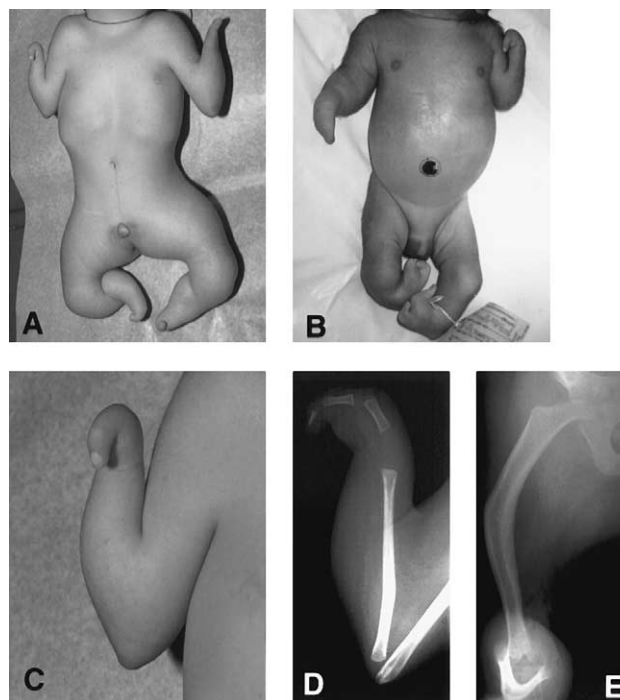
Photographs and radiographs of patients. A, Patient 1. B, Patient 2. Severe symmetric limb malformations are present in all four limbs. A proximal segment or stylopod, an intermediate segment or zeugopod, and a distal segment or autopod are present in each limb. Single digits with a dorsal nail are present in all limbs in patient 1; two digits are present in the feet in patient 2. In patient 1, the external genitalia are represented by a rugous scrotal skin, where no testes were palpable, and a small phallus with a distal urethral opening. Patient 2 has penoscrotal transposition and micropenis. C, Right upper limb of patient 1, showing contractures at the shoulders, elbows, and wrists, that separate the limb into 3 well-defined segments. D, Radiographs of left upper limb of patient 1, demonstrating a thin humerus, a single long bone in the zeugopod, an unossified carpal space, a single metacarpal, and two phalanges. E, Radiographs of right lower limb of patient 1, showing a long bowed femur and a single incurved long bone in the zeugopod phalanges.
